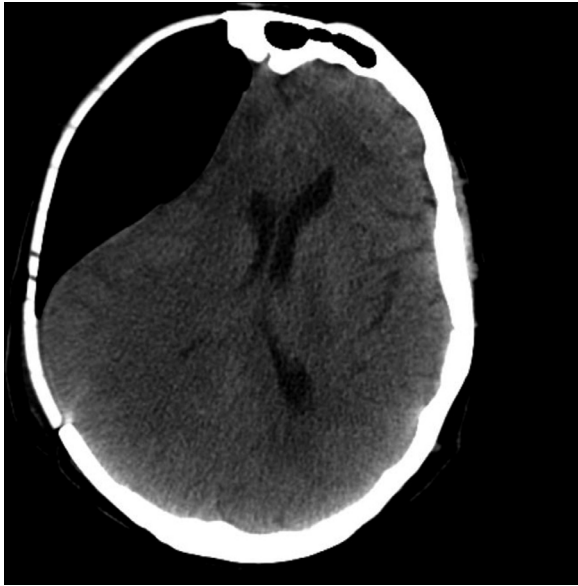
Axial noncontrast CT (NCCT) head at the level of the midbrain demonstrating large amount of extra-axial air resulting in midline shift.
